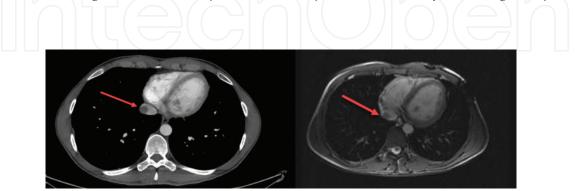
CT scan and Gd-DPTA MRI scan in a 20-year-old male BD patient showing inferior vena cava thrombosis in its supradiaphragmatic segment.
